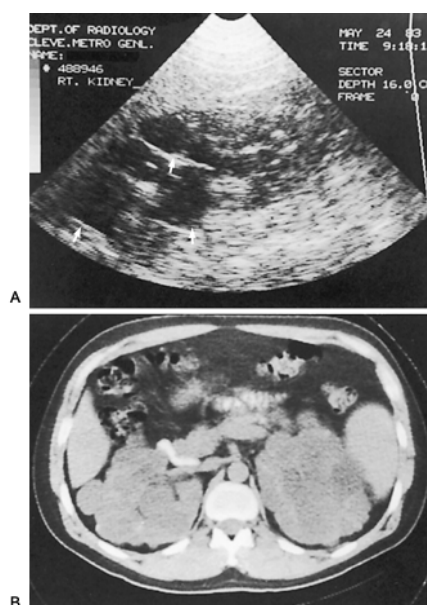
23. A: Transverse scan showing multiple cysts (*arrows*) in an enlarged kidney. Changes typical of adult polycystic kidney disease. B: Computed tomography scan of same patient.
